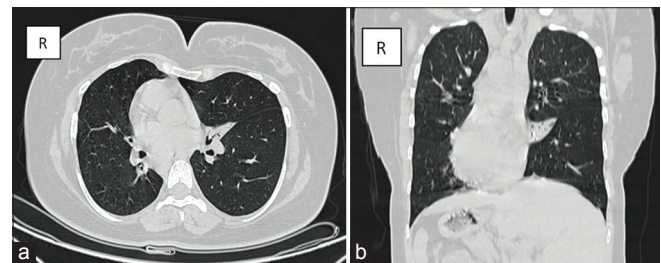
(a and b) Axial (thoracic level) and coronal chest computed tomography section shows collapse of the left middle lobe. The small left middle lobe bronchus is seen inside the collapsed lobe. The horizontal and longitudinal fissure outlines the collapsed left middle lobe
